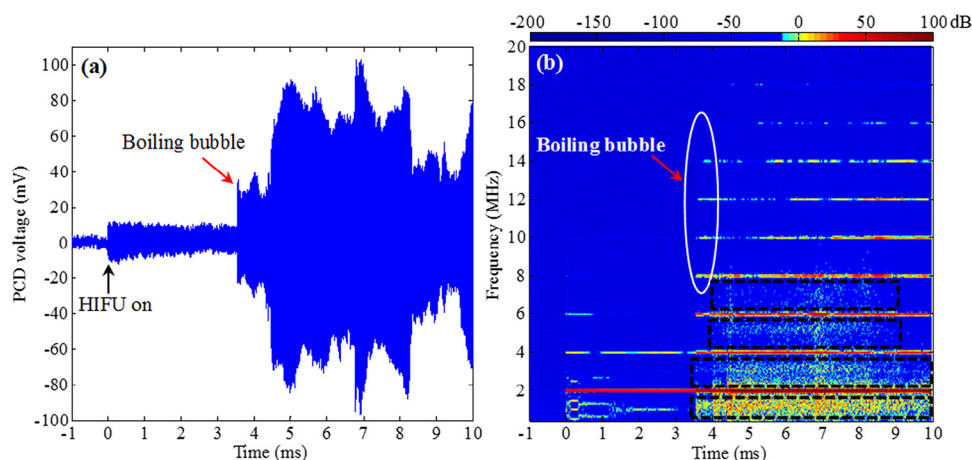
Acoustic signal emitted from the HIFU focus in the gel during the single 10-ms HIFU pulse. (a) The PCD voltage versus time plot and (b) the corresponding spectrogram. Acoustic emissions were recorded at a sampling rate of 0.5 GHz. The time at 0 ms represents the start of the HIFU insonation. HIFU = high-intensity focused ultrasound; PCD = passive cavitation detection.
